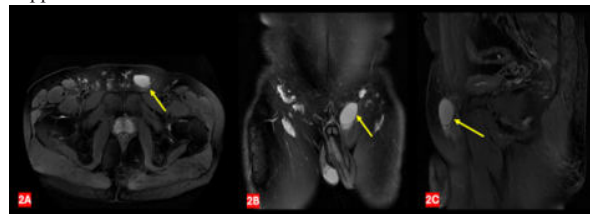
MRI Axial (2A), Coronal (2B), Sagittal (2C) shows left testis in the region of left inguinal region with minimal adjacent T2 hyperintense fluid collection.
